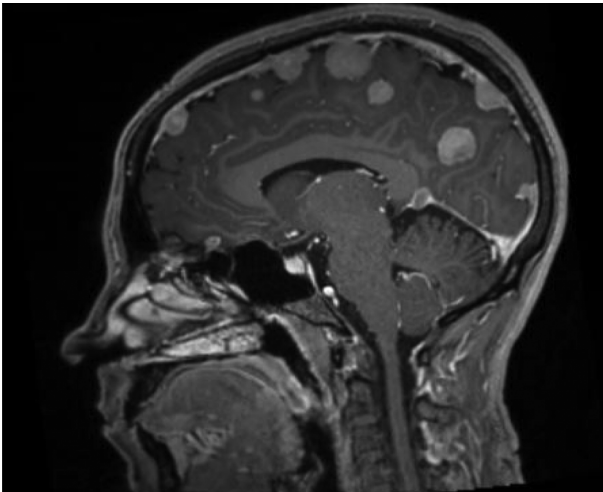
Sagittal T1 C+ (Gd) MRI showed multiple homogeneous and well-circumscribed extra-axial masses with a broad dural base and homogeneous enhancement along the great cerebral falx partially involving the superior sagittal sinus.
